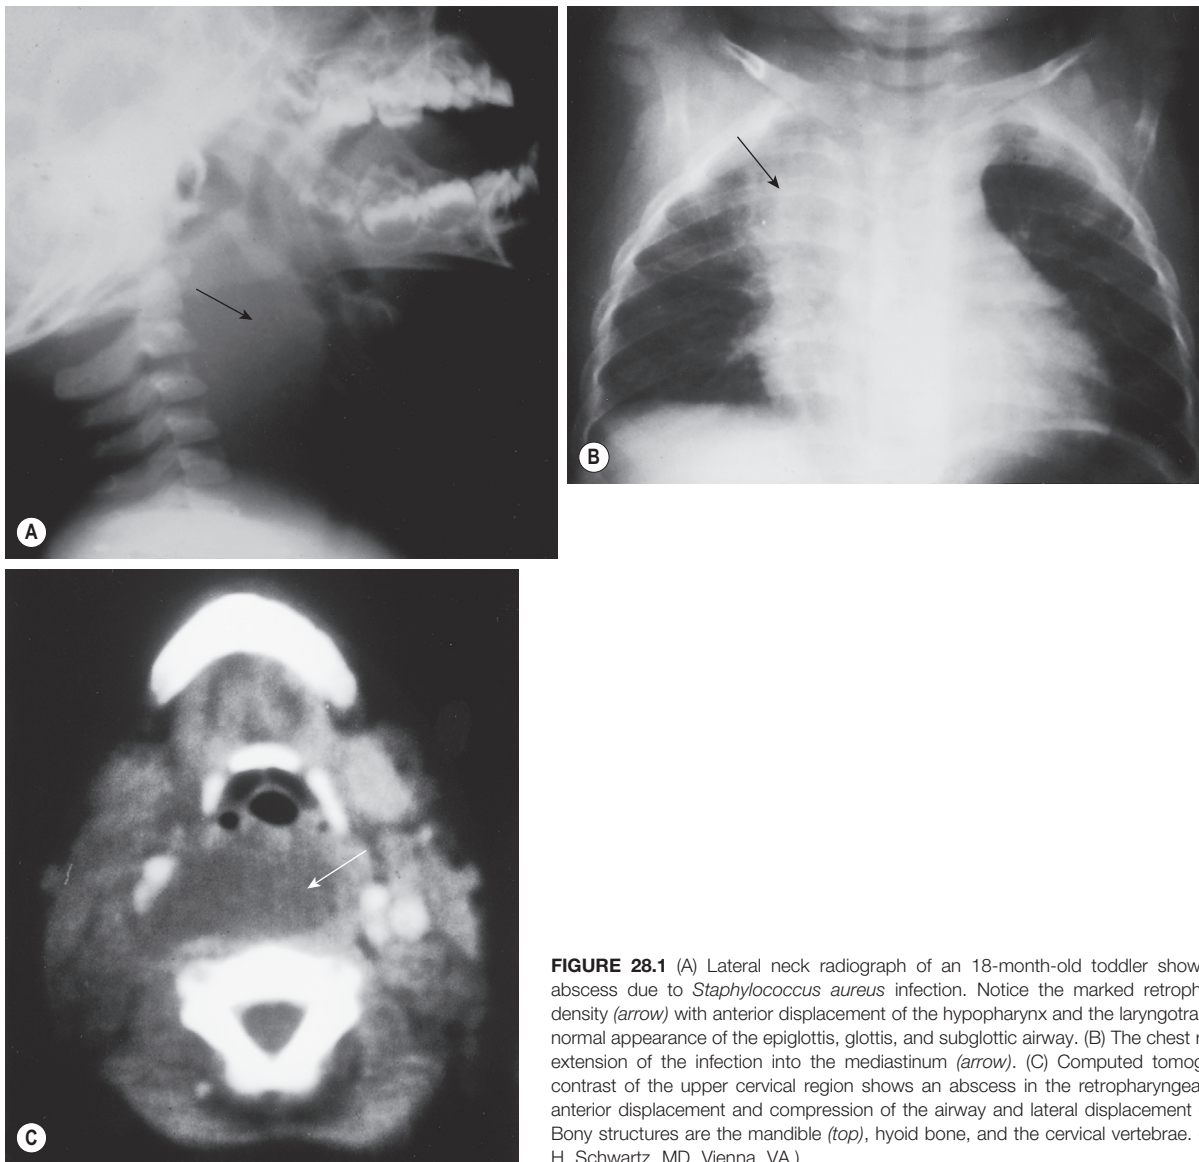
(A) Lateral neck radiograph of an 18-month-old toddler shows a retropharyngeal abscess due to *Staphylococcus aureus* infection. Notice the marked retropharyngeal soft tissue density (arrow) with anterior displacement of the hypopharynx and the laryngotracheal airway and the normal appearance of the epiglottis, glottis, and subglottic airway. (B) The chest radiograph shows an extension of the infection into the mediastinum (arrow). (C) Computed tomography scan without contrast of the upper cervical region shows an abscess in the retropharyngeal space (arrow) with anterior displacement and compression of the airway and lateral displacement of the great vessels. Bony structures are the mandible (top), hyoid bone, and the cervical vertebrae. (Courtesy of Richard H. Schwartz, MD, Vienna, VA.)
